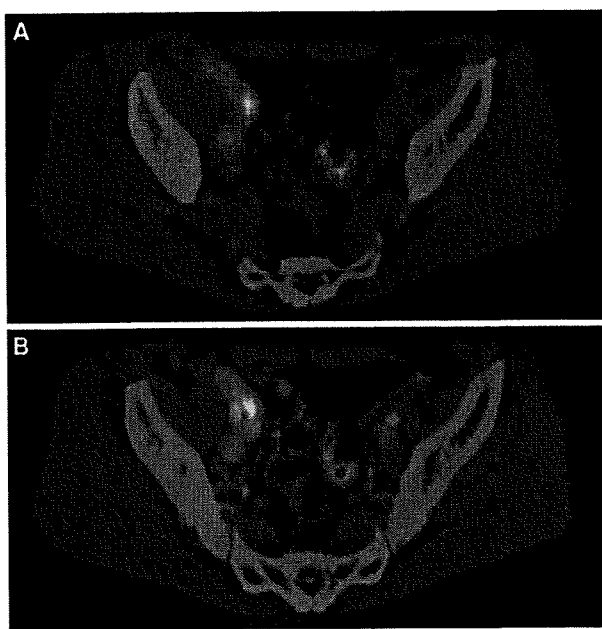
Axial noncontrast PET/CT image (A) and contrast-enhanced PET/CT (B) shows enlarged right internal iliac lymph node with increased uptake in patient with follicular lymphoma. Abnormal uptake is found in the right external iliac area on noncontrast PET/CT, while this uptake corresponds to physiological uptake of jejunum on contrast-enhanced PET/CT.
